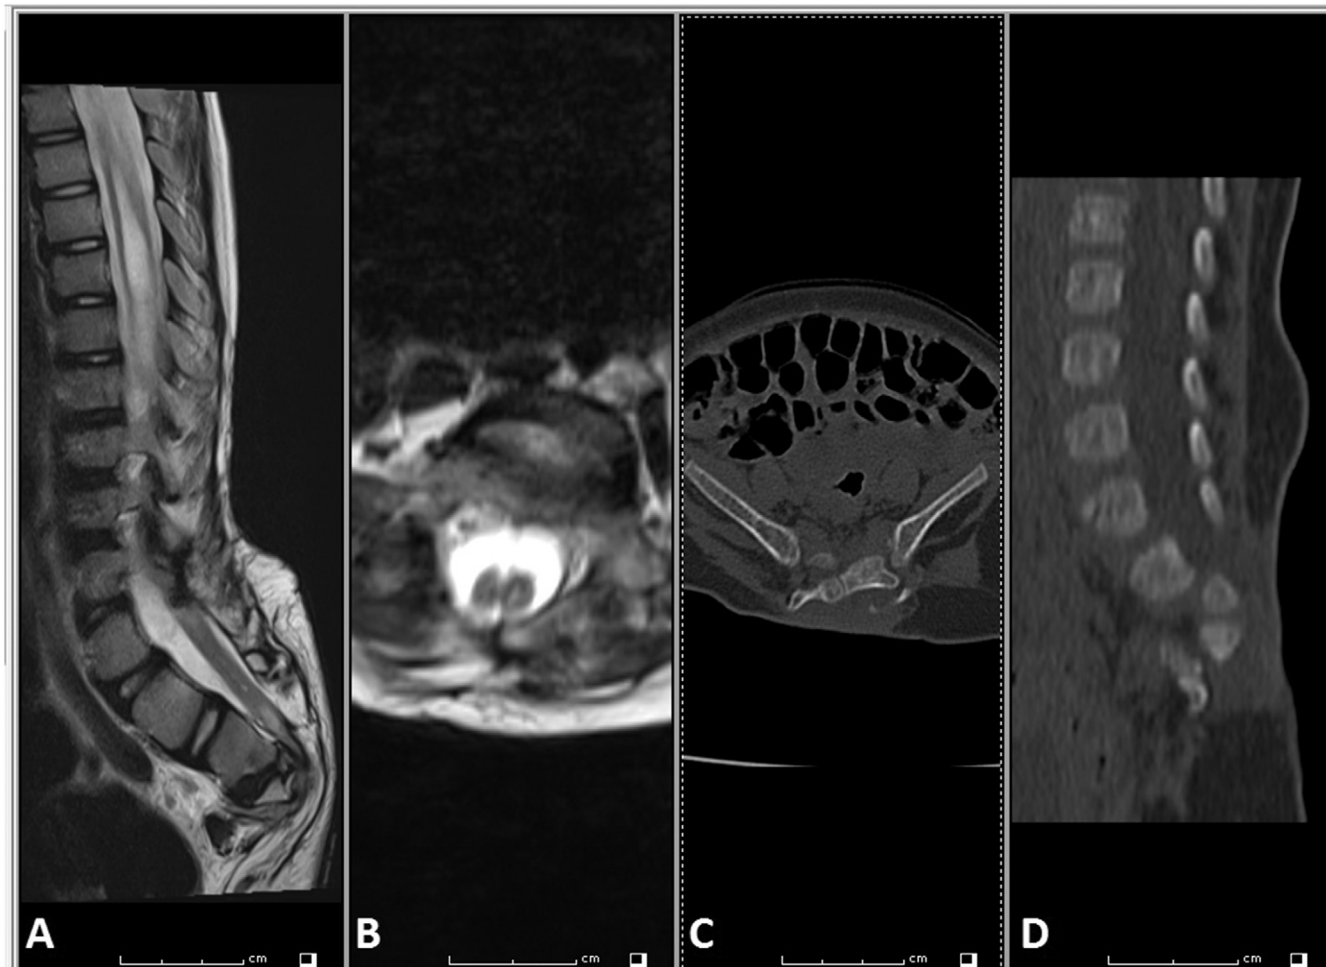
Follow-up MRI of the lumbosacral spine showing (A) the lower extent of the holocord syrinx and a low-lying, tethered conus on sagittal T2 sequence; (B) T2-weighted axial section at L4 demonstrating a split cord malformation with two evident holocords. CT images of the lumbosacral spine showing (C, D) the absence of L5, S1, and S2 and the sacral vertebrae, and incompletely formed posterior elements.
